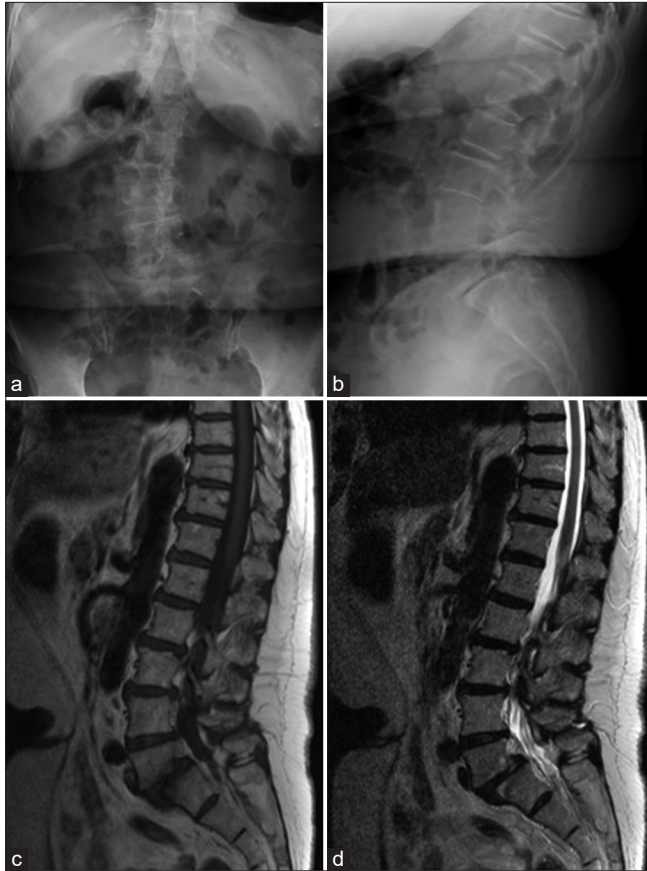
Anteroposterior (a) and lateral (b) radiographs of the lumbar spine before lumbosacral fusion demonstrated isthmic spondylolisthesis at L5/S1 with mild scoliosis. T1- (c) and T2-weighted images (d) showed isthmic spondylolisthesis of L5 on S1.
